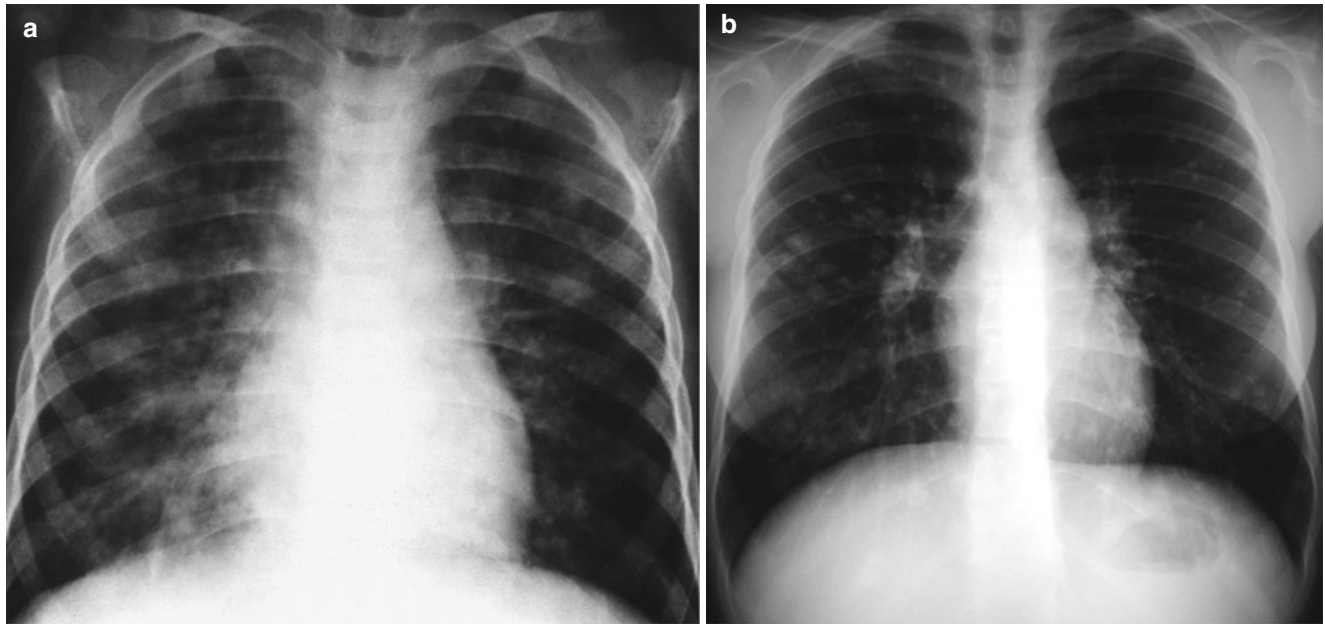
Varicella pneumonia. Frontal chest radiograph of a 5-year-old boy showing multifocal patchy, nodular infiltrates throughout both lung fields (a). School requirement chest x-ray of a 15-year-old
